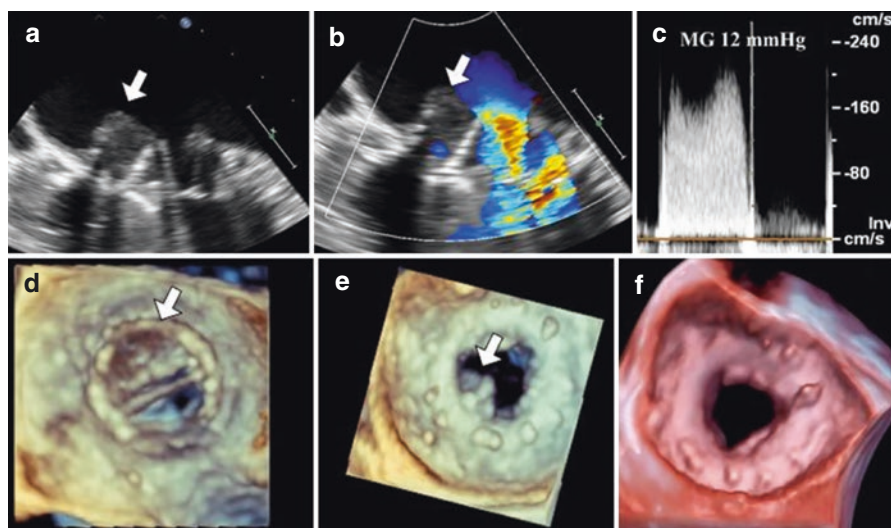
Prosthetic mitral valve thrombosis. A patient with mechanical mitral valve thrombosis (panels a–d). A large thrombus (arrow) is seen on 2D transesophageal echocardiogram (panel a) that obstructs the flow (arrow) and results in filling only through the opening of the non-obstructed strut of the valve (panel b). Elevated transmitral gradients are seen (panel c). Three-dimensional transesophageal echocardiogram confirms immobility of the obstructed strut (panel d). A patient with bioprosthetic mitral valve thrombosis (panels e, f). An immobile leaflet of the valve is seen on 3D transesophageal echocardiogram due to thrombosis (panel e). Complete restoration of leaflet mobility and normal valve functioning are seen after 6 weeks of anticoagulation with a vitamin K antagonist (panel f)
